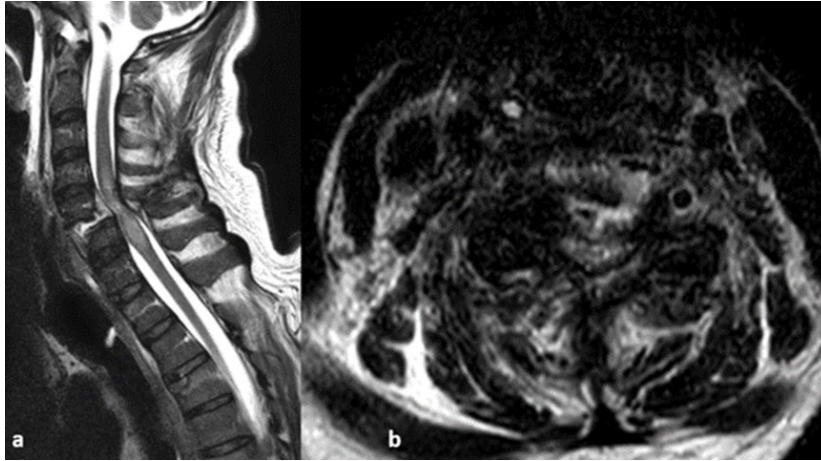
In the sagittal view of the cervical MRI (T2 weighted), there is evident anterolisthesis at the C5/C6 level, along with an injury to the posterior ligamentous complex (PLC) and the presence of spinal cord oedema.
